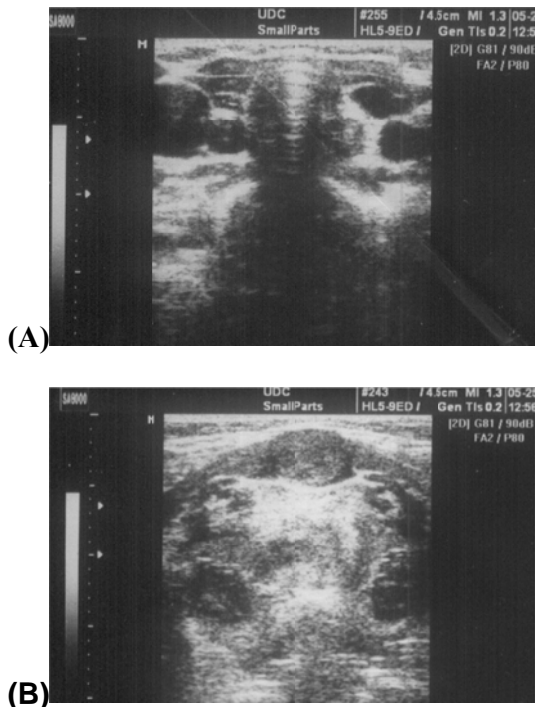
Ultrasound showing (A) absent normal thyroid gland in its normal anatomic position and (B) soft tissue nodule slightly echogenic to overlying strap muscle. (This is the same patient seen in Fig. 3).
